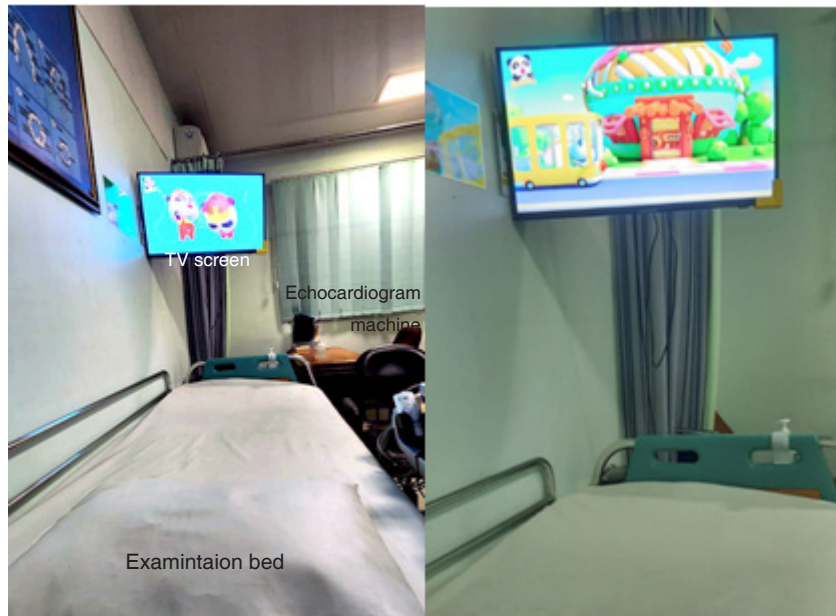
Examination room. (A) Position of examination bed, ceiling-mounted TV screen, and echocardiogram machine. (B) Photograph from the patient's point of view.
